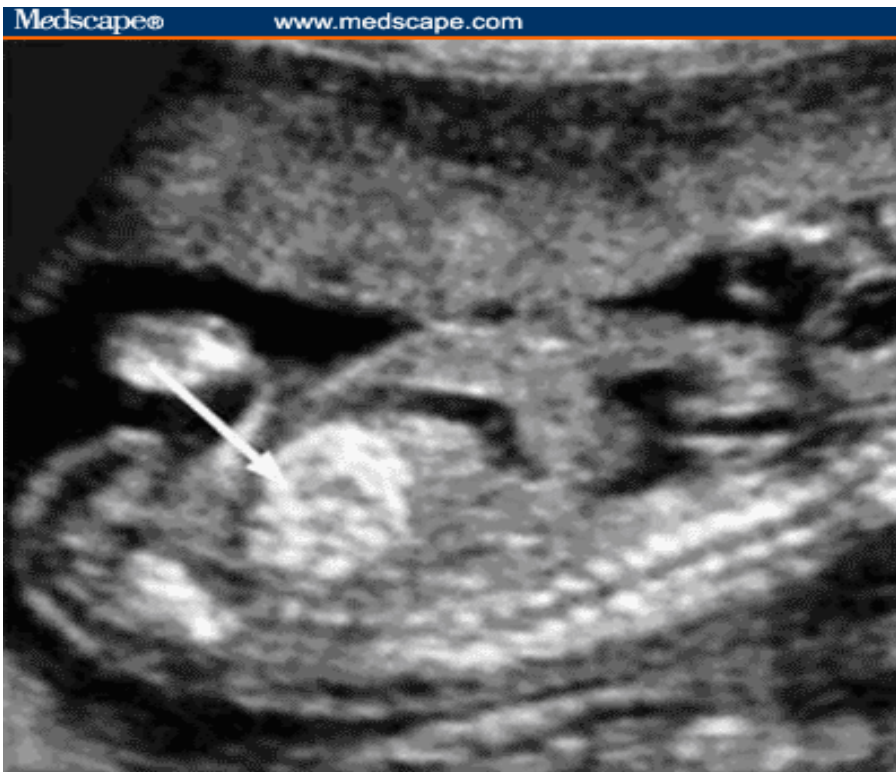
Echogenic bowel. Early second trimester ultrasound scan, in which the bowel (arrow) appears to be as bright as adjacent bone.(echogenic). The fetal spine can be seen across the bottom of the image.
